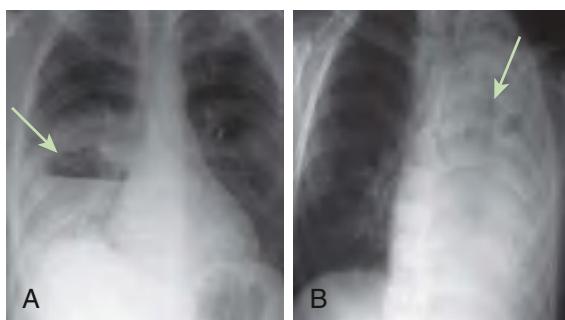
Chest radiographs of lung abscess and necrotizing pneumonia. A, Lung abscess. A single thick walled, irregular cavity containing an air-fluid level can be seen (arrow). B, Necrotizing pneumonia. A completely opacified left hemithorax with multiple necrotic areas can be seen (arrow). (From de Benedictis FM, Kerem E, Chang AB, et al. Complicated pneumonia in children. Lancet. 2010;396:786–798, Fig. 2, p. 789.)
